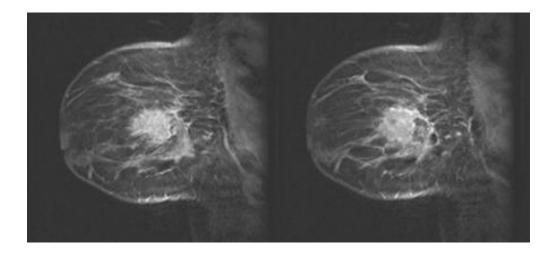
MRI breast image prior to histogram equalisation
